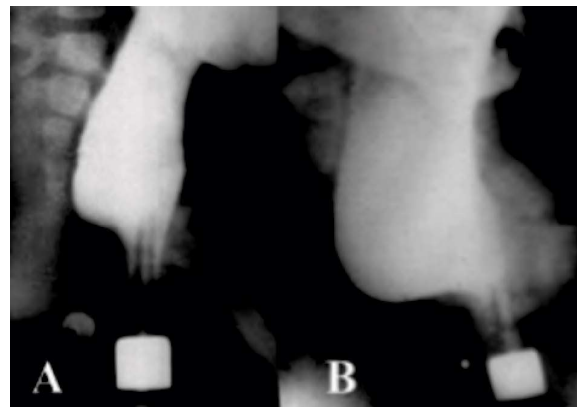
Lateral radiographs of the anorectal area of the same patient with vestibular fistula. A. At the age of six months. Penetration of barium behind the tip of the enema is observed, testifying to weakness of the PRM. However, the length of the RND is within the limits of the age norm. B. At the age of one year and two months. Expansion of the rectum is combined with a sharp shortening of the RND between the marker near the activity of the external anal sphincter (fraction) and the ARA.
